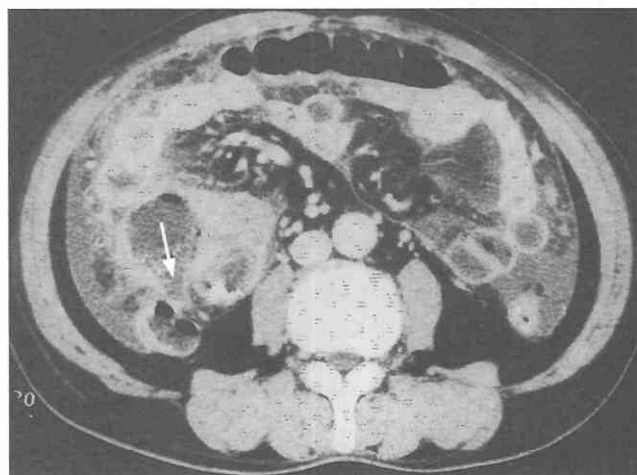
Perforated small-bowel lymphoma after chemotherapy. On CT scan, the bowel wall involved with lymphoma is focally perforated (*arrow*) along with evidence of a large amount of ascites and diffuse omental infiltration.
